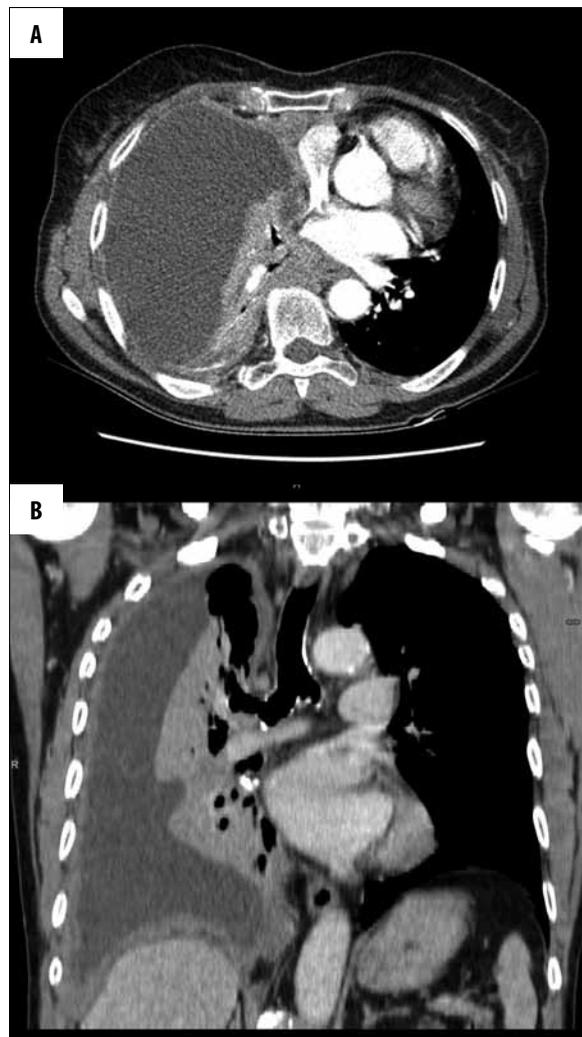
Chest CT. (A) Axial plane. (B) MPR reconstruction. Large right pleural effusion compressing the lung.
